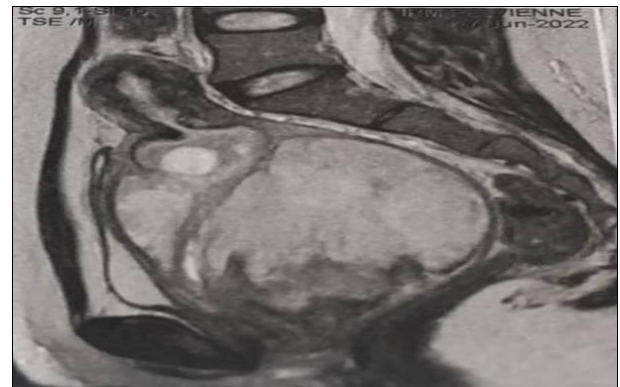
MRI showing a solid-cystic mass in the uterine cavity
